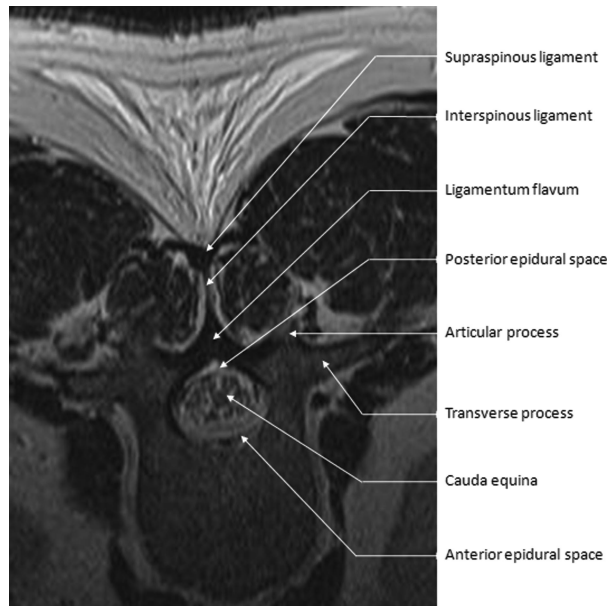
Transverse (axial) magnetic resonance imaging (MRI) view of a lumbar vertebra at the level of the interlaminar space. In this T1-weighted image, fat (subcutaneous tissue, epidural space), and fluid appear white; connective tissue (ligaments, dura) and muscle appear dark. The vertebral canal contains the epidural space, thecal sac (seen as a dark outline between epidural space and cerebrospinal fluid), and cauda equina. Note the arch-like structure of the ligamentum flavum and the triangular cross-section of the posterior epidural space immediately deep to it. (Image used with permission from www.usra.ca.)
